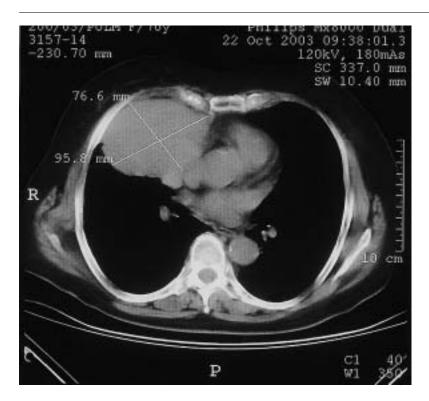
A preoperative CT scan of the tumor.
